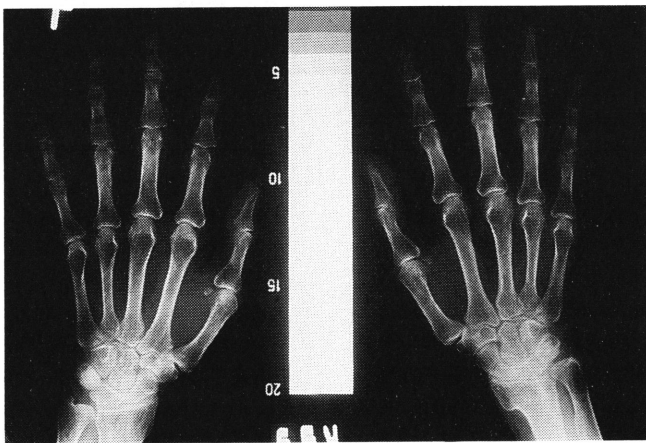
X-ray of the second metacarpal bone a grade II bone atrophy (score 12)
